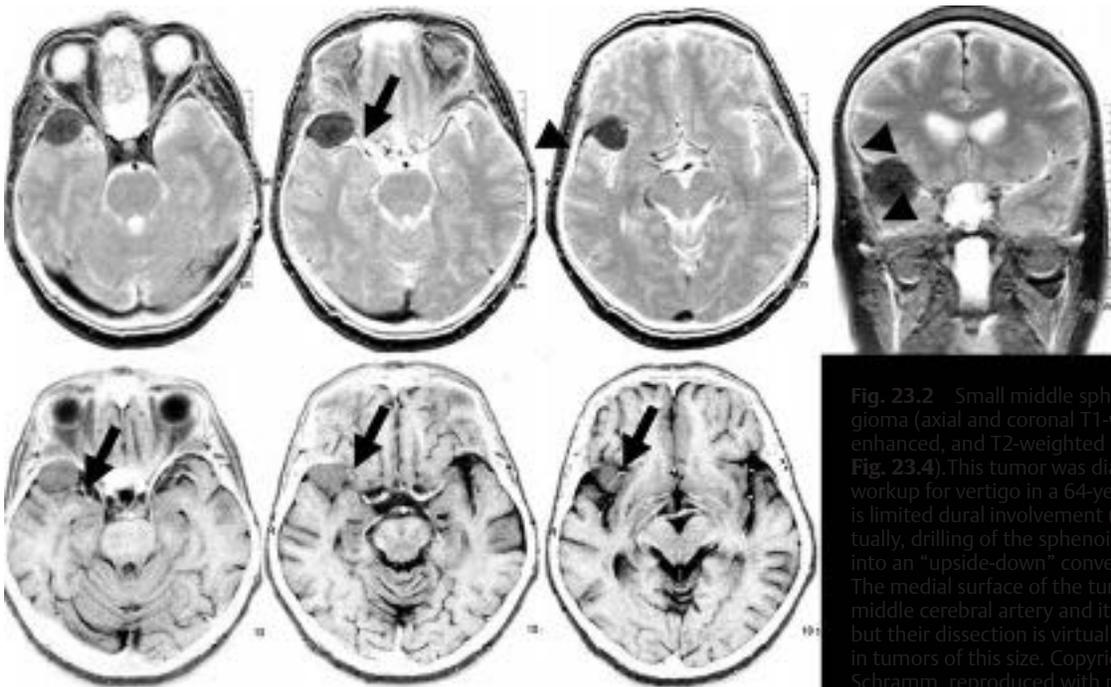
Small middle sphenoid wing meningioma (axial and coronal T1-weighted contrast-enhanced, and T2-weighted axial scans; compare Fig. 23.4). This tumor was diagnosed during the workup for vertigo in a 64-year-old female. There is limited dural involvement (*arrowheads*). Conceptually, drilling of the sphenoid can turn this tumor into an "upside-down" convexity meningioma. The medial surface of the tumor is related to the middle cerebral artery and its branches (*arrows*), but their dissection is virtually never a problem in tumors of this size. Copyright M. Simon and J. Schramm, reproduced with permission.
